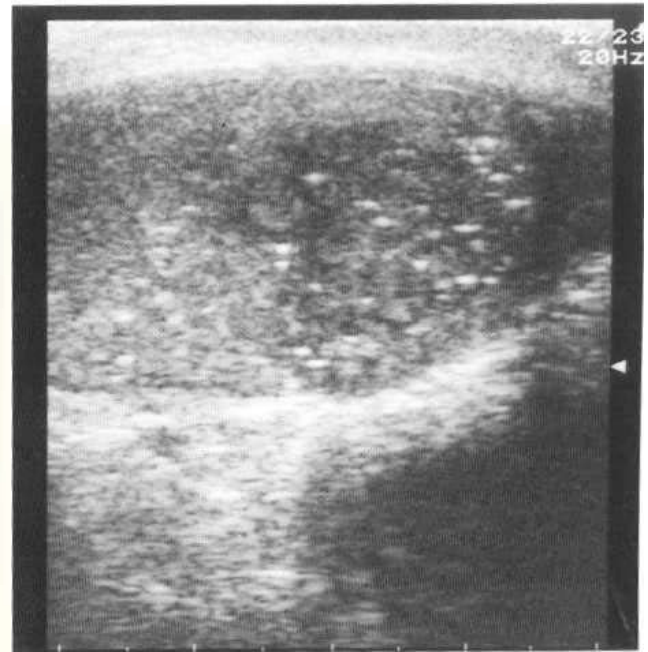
Testicular ultrasound showing microlithiasis and the development of a seminoma.
